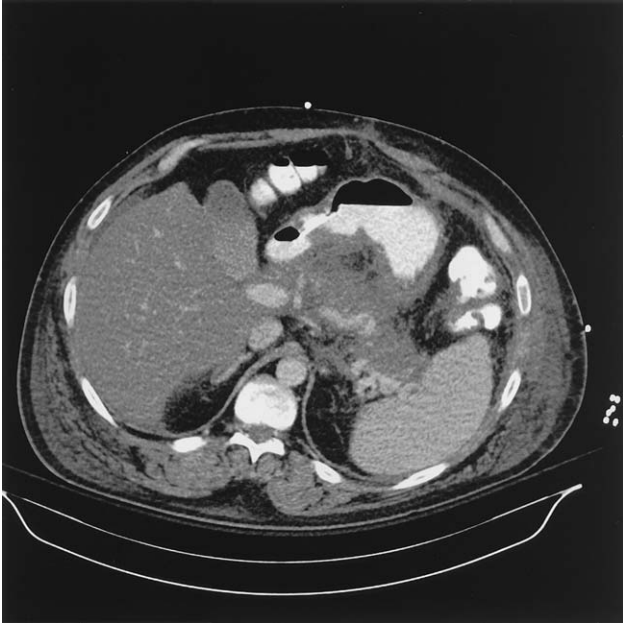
Contrast-enhanced abdominal computed tomography scan in the 47-year-old man shown in Fig. 1 with a second episode of acute pancreatitis. Scan shows stranding of peripancreatic fat, consistent with acute pancreatitis. Most notable is the near-complete absence of pancreatic enhancement, diagnostic of pancreatic necrosis.
